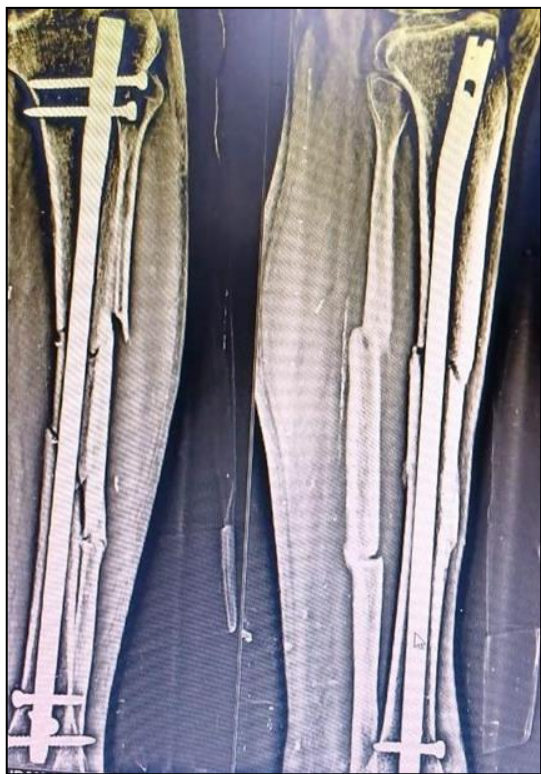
Postoperative radiograph of fracture lower & middle 1/3rd Jn. Tibia
